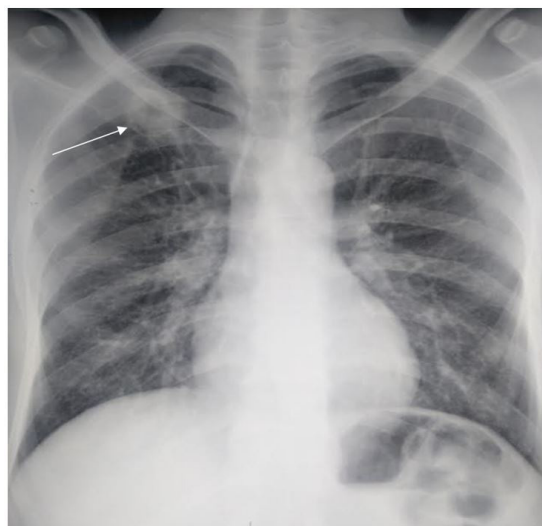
Chest radiograph showing an opaque shadow lesion (arrow) with cavitation involving the right upper lobe
